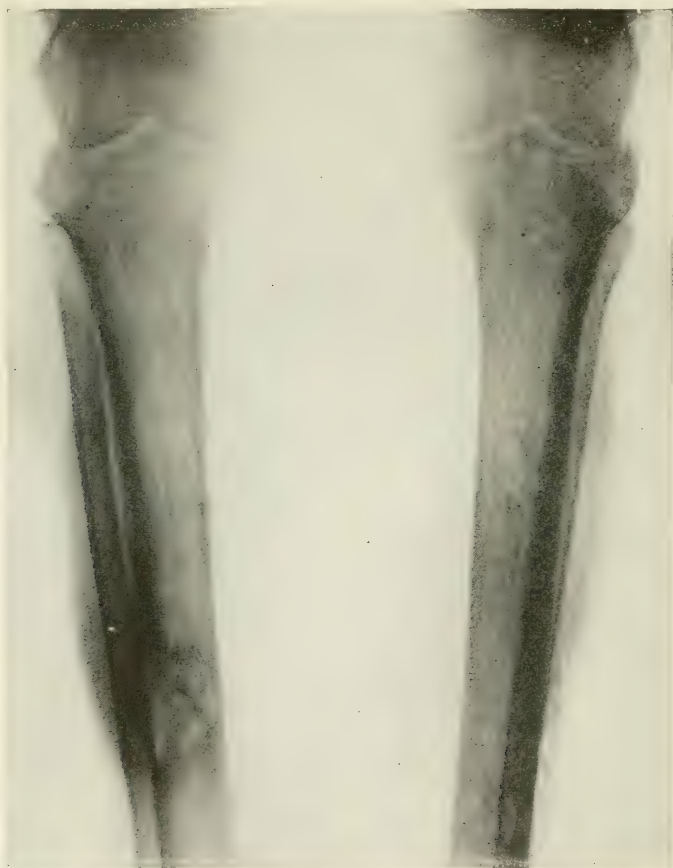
X-ray showing large area of osteolysis in left tibia; areas of osteolysis and translucency in right tibia. (Barrie.)
